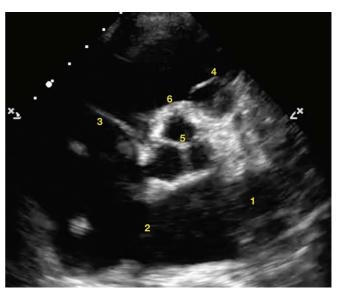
Parasternal short axis window at the level of the aortic valve. Figure courtesy of Alan Chiem.
